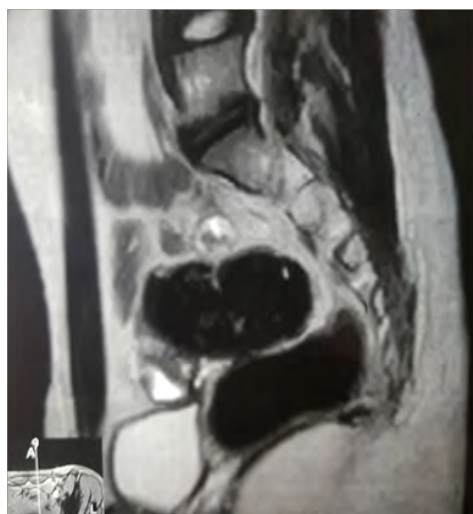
MRI profile section showing absence of the uterus with visible presence of two ovaries (Patient 3).
